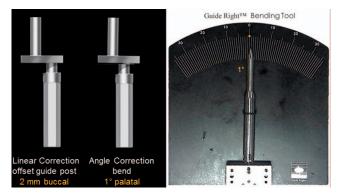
Virtual planning in the CBCT cross-section at site #13 determined that a 2.0-mm buccal offset would be necessary and a  $1^{\circ}$  palatal angle correction to ideally position the implant prosthetically.
